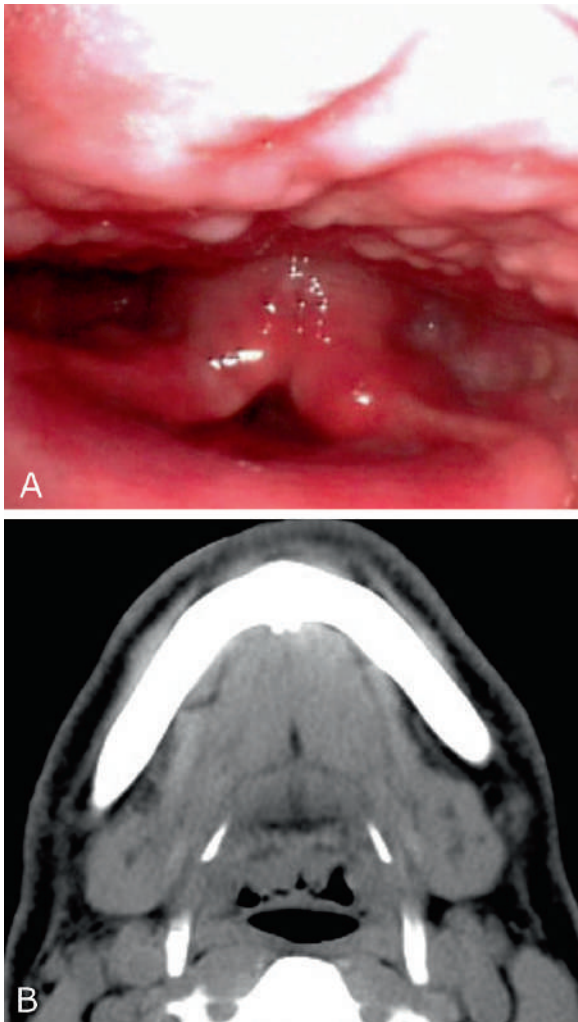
Bronchoscopic image (a) correlated with axial CT image (b) of the hypopharynx shows multiple submucosal nodules. After biopsy these lesions, the results stated that these nodules are composed of hyaline lipid material deposited within the submucosa. The nodules in (b) are almost completely replacing the valleculae (arrowheads)
